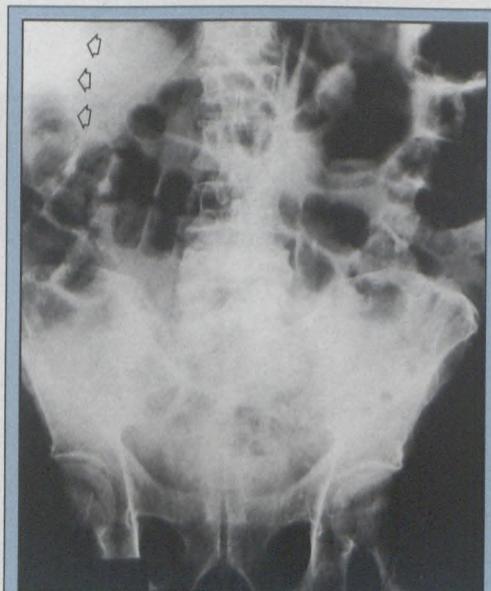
Supine abdominal radiograph with 'liver overlap sign' (arrows) of sigmoid volvulus masquerading as 'football sign' of intraperitoneal free air. Confirmed as sigmoid volvulus (cf. Figure 1c).
